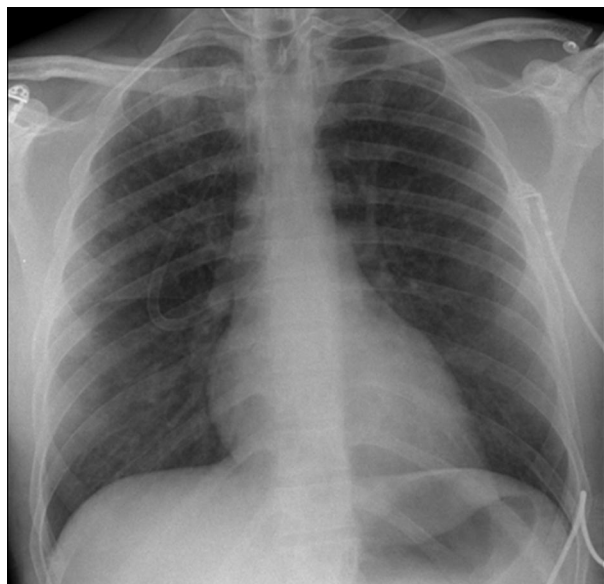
Chest radiograph taken in the postoperative recovery room, revealing diffuse, bilateral, hazy, and interstitial opacity throughout both lungs, with increased visibility of small lung vessels, normal lung volumes, normal heart size, and no pleural effusions.
